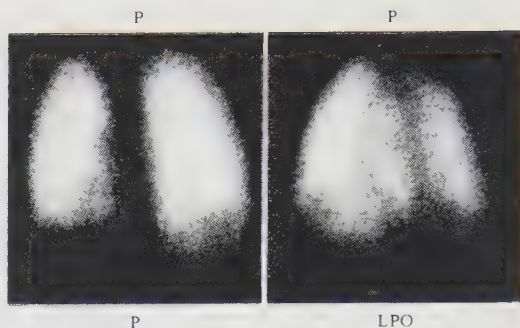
Perfusion scintigraphy after 1 week of the same patient as in Fig. 2. Compare the diffuse shape of the defect (d_3) in the LPO projection with that of Fig. 2
